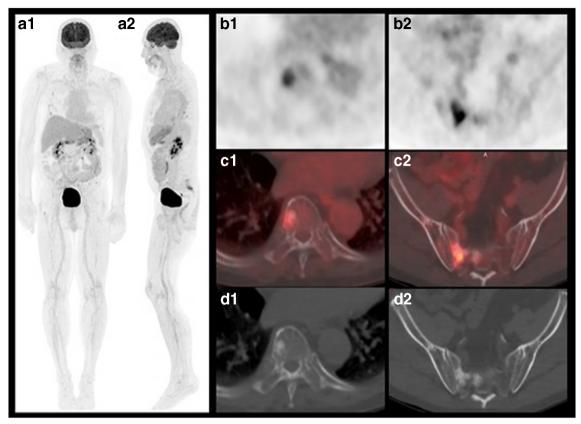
Sixty-nine-year-old male with metastatic PCa on androgen deprivation therapy. Maximal intensity projection (A1, A2), axial PET (B1, B2), axial fused PET/CT (C1, C2), and axial CT (D1, D2) images demonstrates FDG-avid sclerotic bone lesions in the right T8 vertebra body and sacrum
